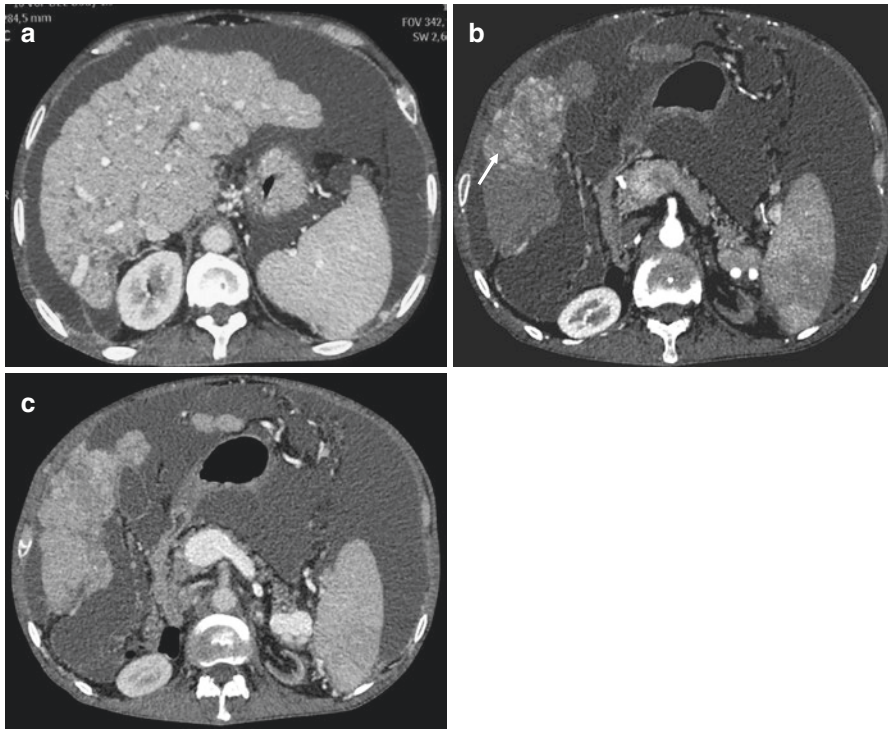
Contrast-enhanced CT scan in a 59-year-old patient with BCS. (a) HV and IVC obstruction and decompensated cirrhosis with ascites; (b) A 65 mm HCC located in the paravesicular segment V, heterogeneous, hypervascular on the arterial phase; (c) Early washout of the lesion on the portal phase (with courtesy of Pr SA. Faraoun)
